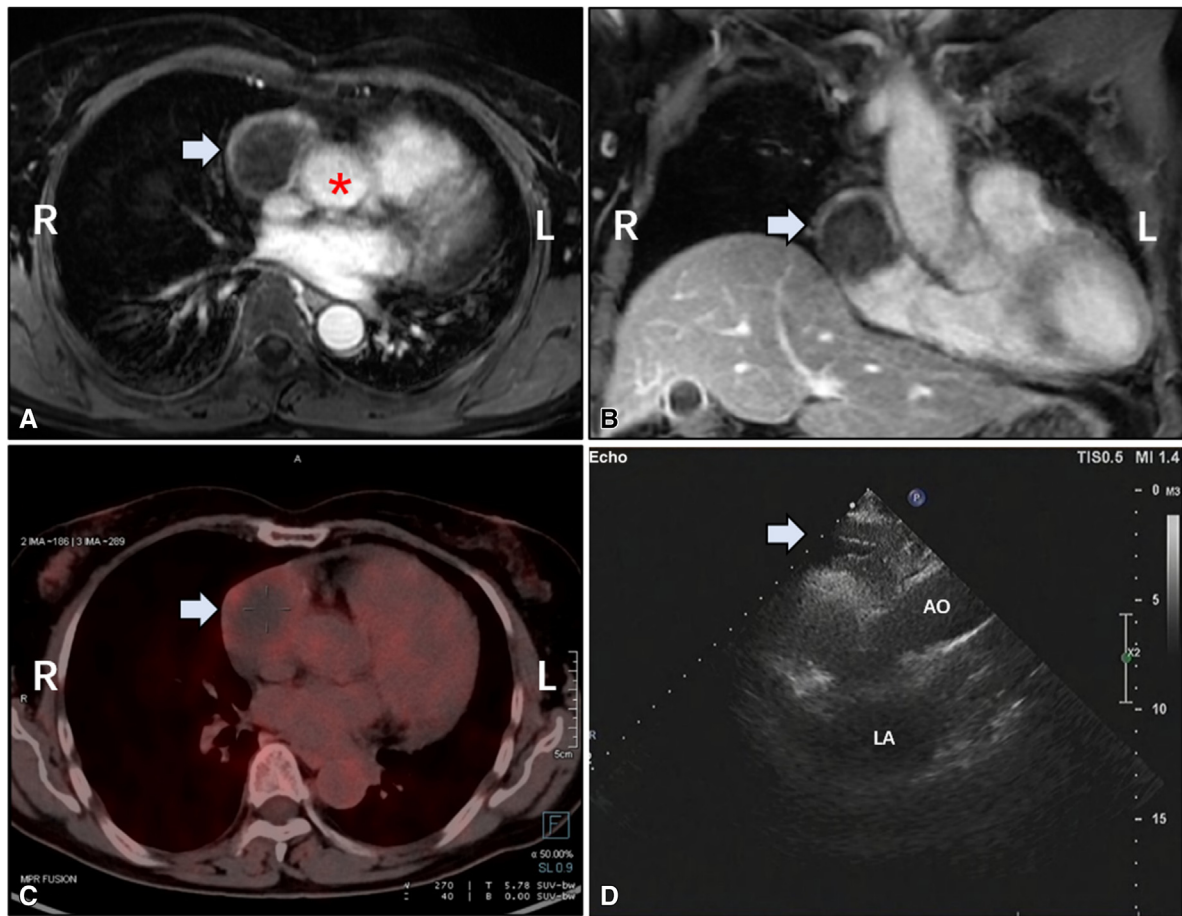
Thoracic magnetic resonance imaging scans showed an anterior mediastinal mass (arrow) of cystic density from transverse view (A) and coronal view (B). The aortic root (asterisk) and the arrow indicates the mass. Positron emission tomography (PET) depicting a solitary well-defined mass with homogeneous enhancement adjacent to the aorta (C). The mass was visible in the echocardiography study (arrow) (D). AO, Aorta; LA, left atrium.
